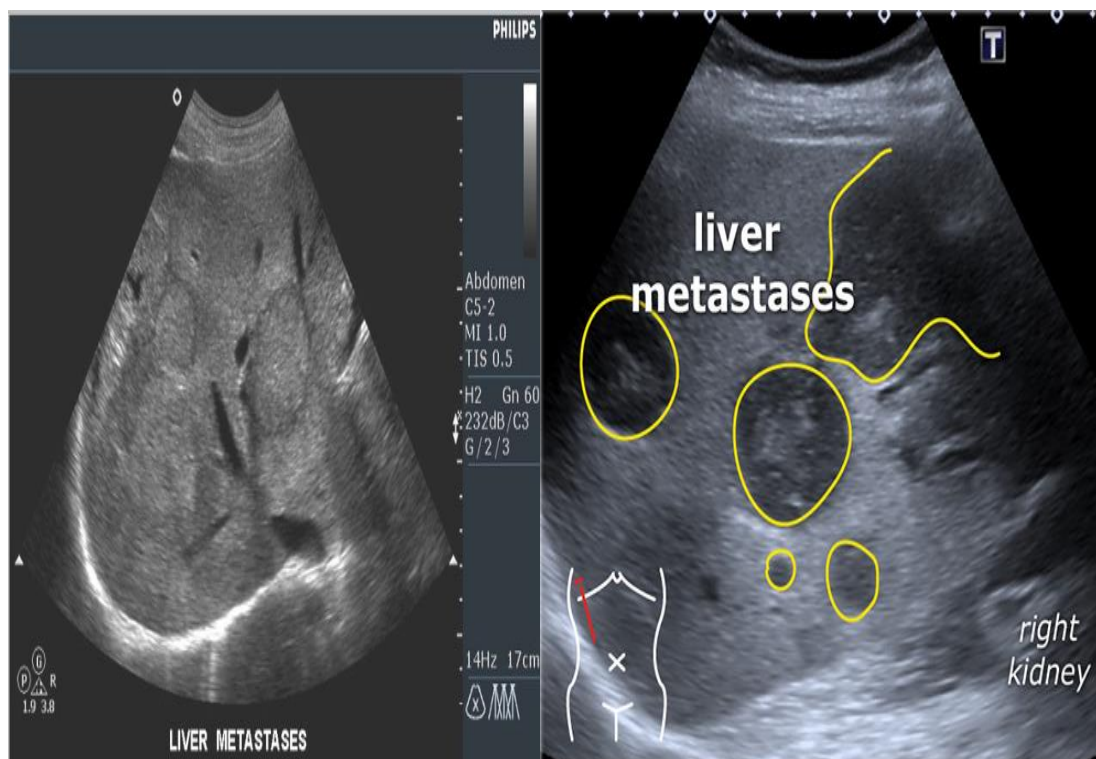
(a) Sonogram of Metastases liver (b) Sonogram findings of Liver metastases
